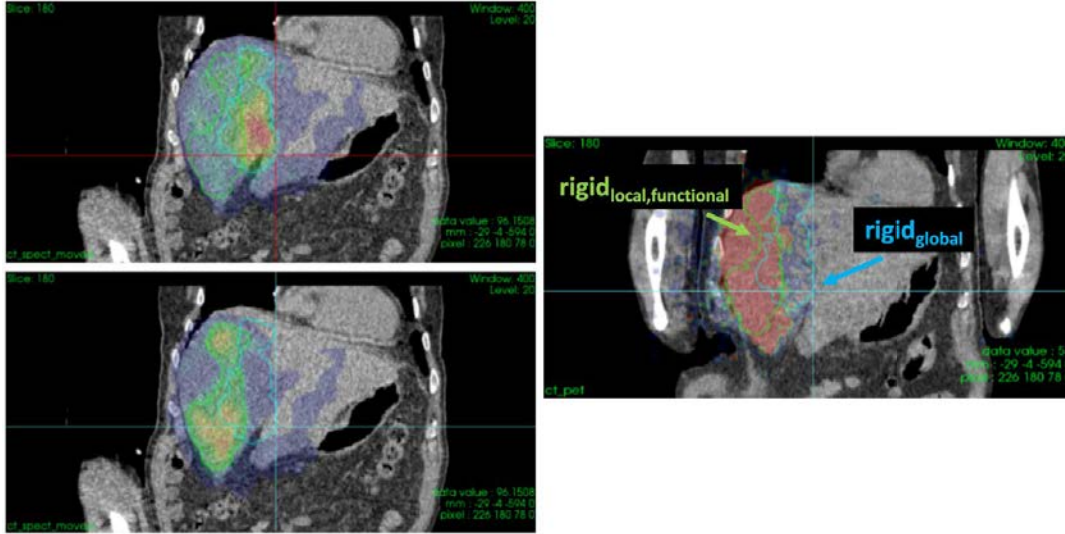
The  $RT\text{-}struct_{PET}$  obtained from the propagated  $RT\text{-}struct_{SPECT}$  for the  $TV_{Total}$ , following the  $rigid_{global}$  (cyan) and  $rigid_{local,functional}$  (green) transformations. *Top-left*: The SPECT/CT following the  $rigid_{global}$  method. *Bottom-left*: The SPECT/CT following the  $rigid_{local,functional}$  method. *Right*: The PET/CT and position of the propagated  $TV_{Total}$  if the  $rigid_{global}$  (cyan) and  $rigid_{local,functional}$  (green) transformations are used. The position of the  $TV_{Total}$  falls outside the perfused region using the  $rigid_{global}$  method.
